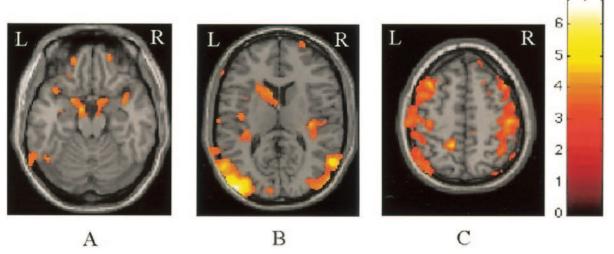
Color-coded areas (SPMt) of brain atrophy development in PPMS overlaid on a template T1-weighted image. *A* shows the involvement of the left middle occipital gyrus, bilateral parahippocampal gyri, and bilateral prepontine and quadrigeminal cisterns. *B* shows the involvement of the head of the left caudate nucleus, insula, and bilateral middle temporal gyrus. *C* shows the involvement of the bilateral central sulci (precentral and postcentral gyri) and regions of frontal and parietal cortex.
